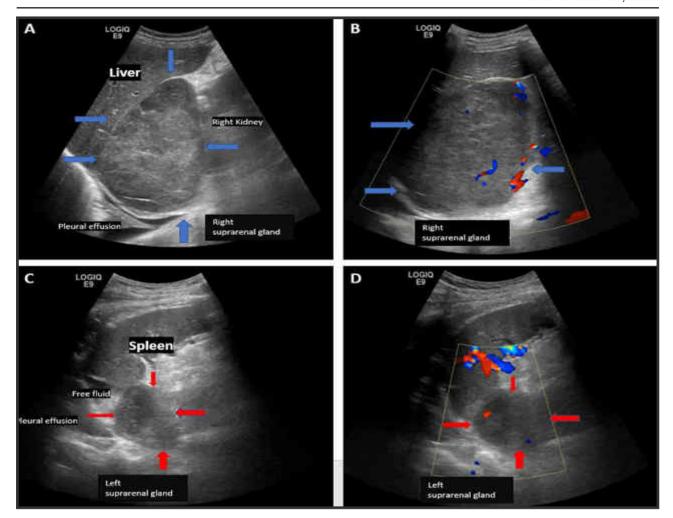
Ultrasound abdomen
